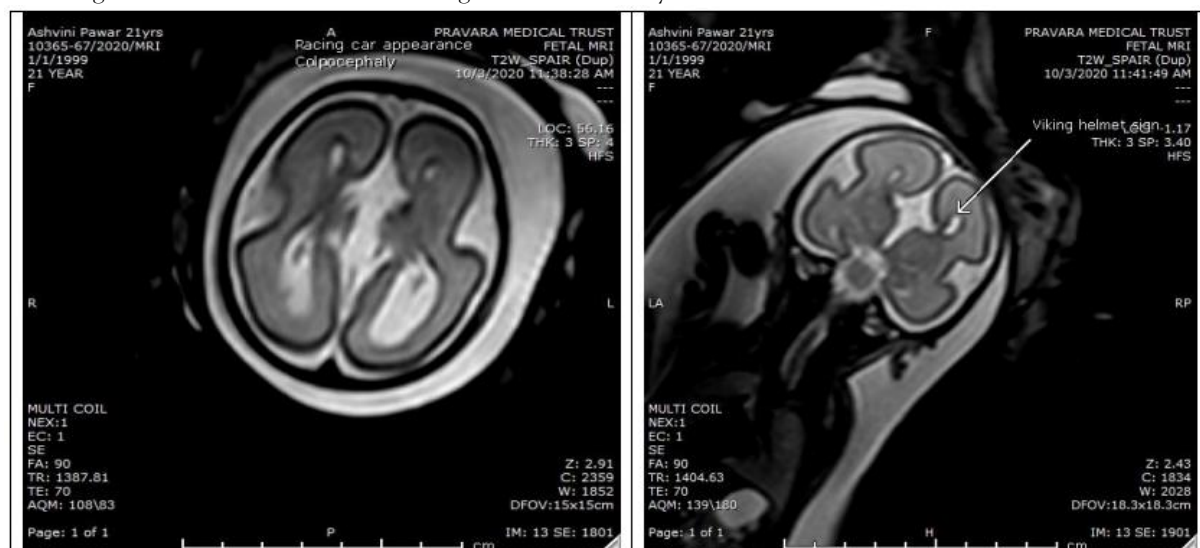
Fetal MRI Signs of Corpus Callosum Agenesis at 22 Weeks Gestation
